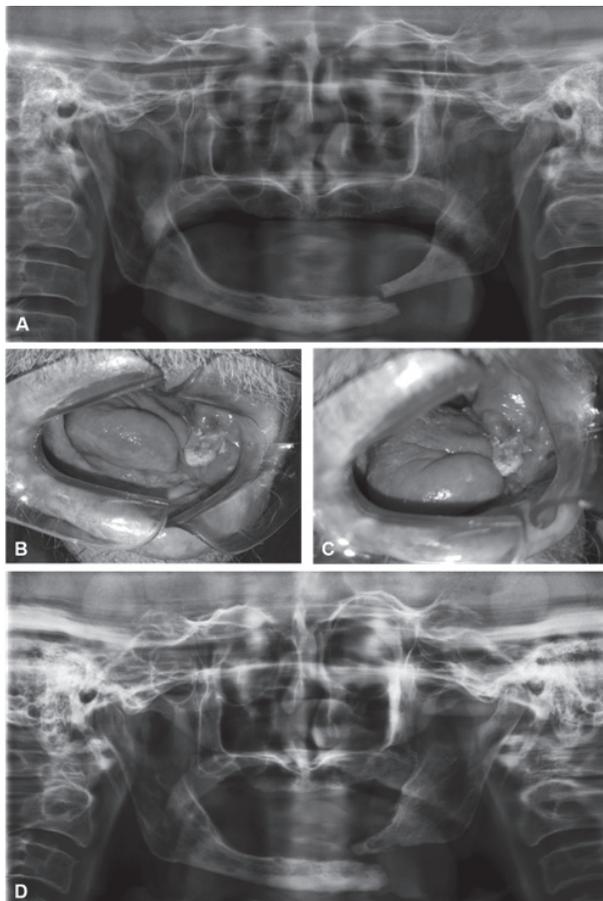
A. Panoramic radiography two weeks after radiotherapy showing mandibular fracture; B and C. Intraoral photos of the exposure of left mandible distal bone stump ten days after the diagnosis of the fracture; D. Panoramic radiography after 11 months of the diagnosis of mandibular fracture.
